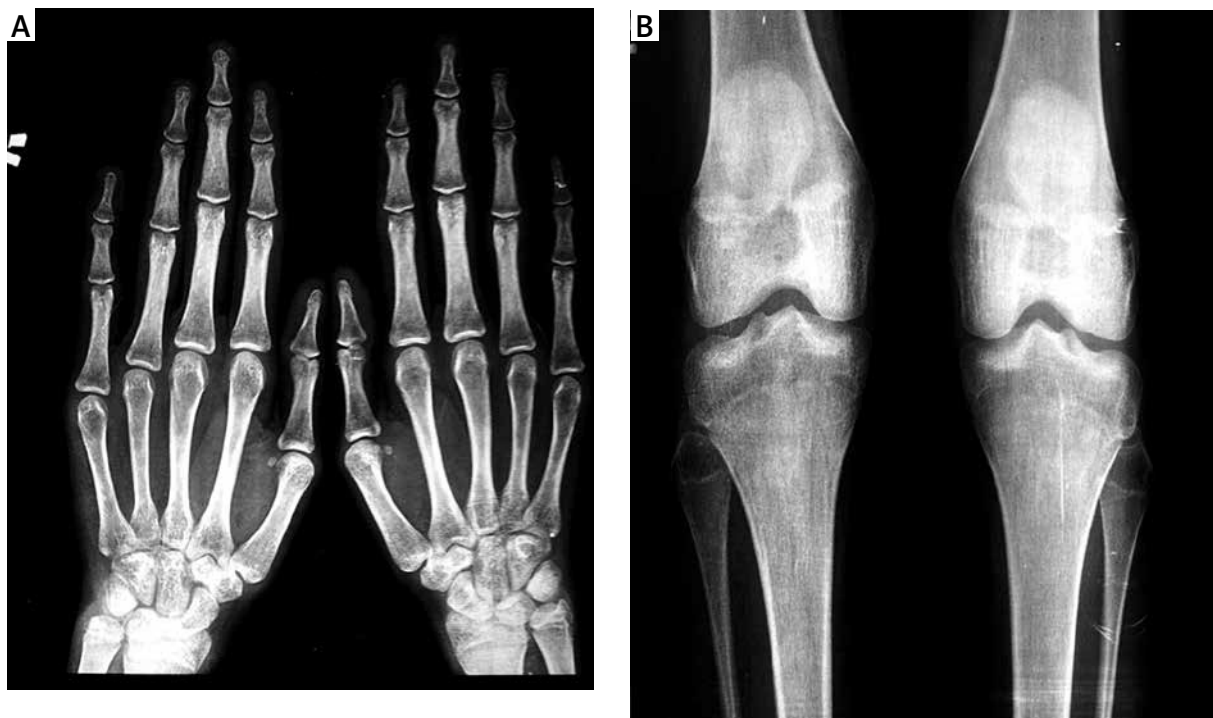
X-rays of bilateral hands and knees, which were normal.
